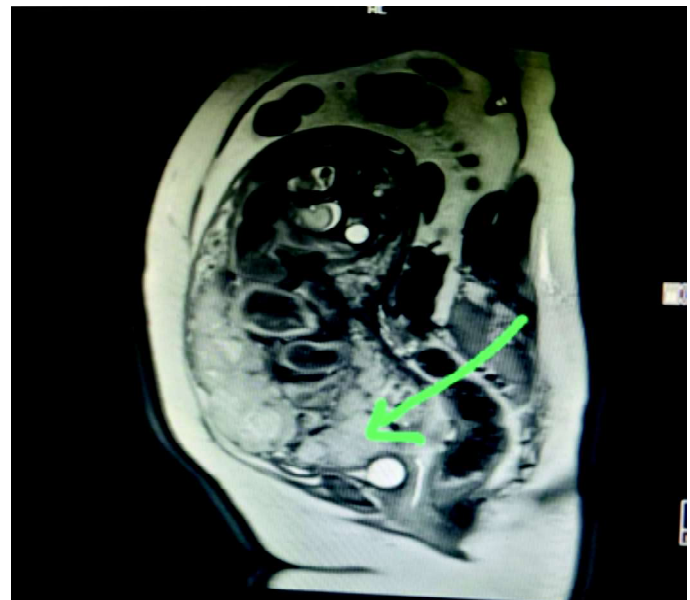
MRI suggestive of placenta percreta (green arrow)
